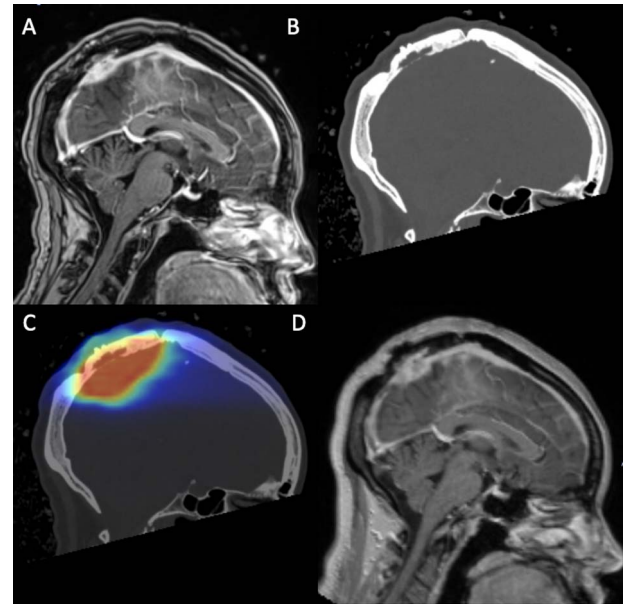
Case 2 at initial presentation and subsequent follow-up of osteolytic lesion; (A) T1 post-contrast MRI and (B) comparable CT sagittal slices obtained 3 months after the development of the lytic bone lesion; (C) the radiation isodose is overlaid on the preceding CT showing that the high-dose region (red) corresponds to the location of the osteolytic lesion (presumed ORN) in this case; (D) sagittal T1 post-contrast MRI slice at 9 months after the development of the lytic bone lesion.
